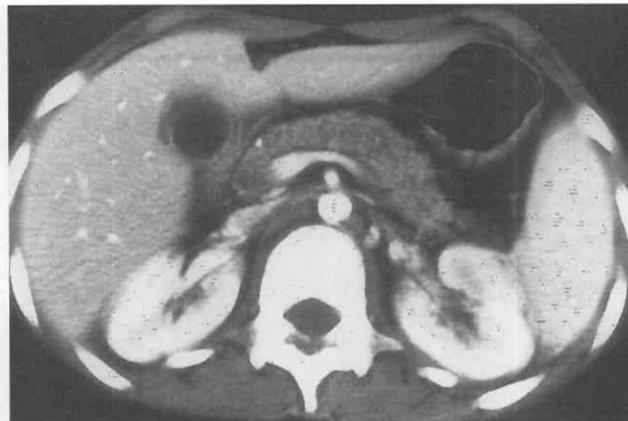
Acute pancreatitis with fluid in the anterior pararenal space. CT scan through the pancreas in a patient with recurrent episodes of acute pancreatitis demonstrates fluid in the anterior pararenal space. There is a punctate parenchymal calcification in the head of the pancreas, likely secondary to prior inflammatory episodes.
